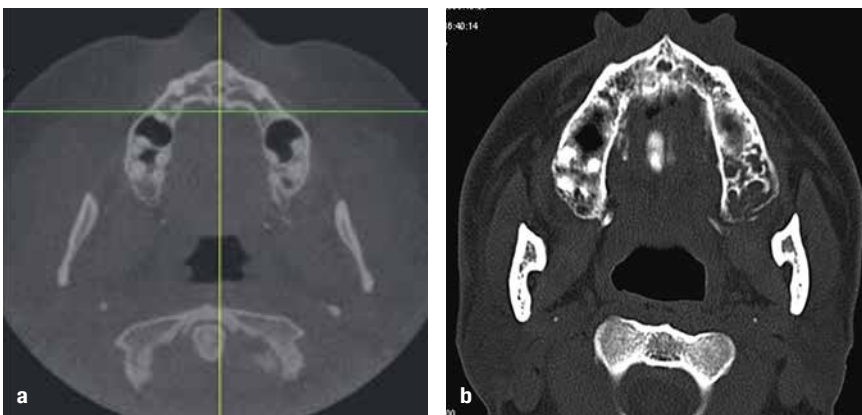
(a) A CBCT axial section at the level of the maxilla compared to (b) a medical CT axial section at the same level. Note the difference in the soft tissue contrast (much higher in the medical CT scan) because of the higher contrast resolution (many more shades of gray).
